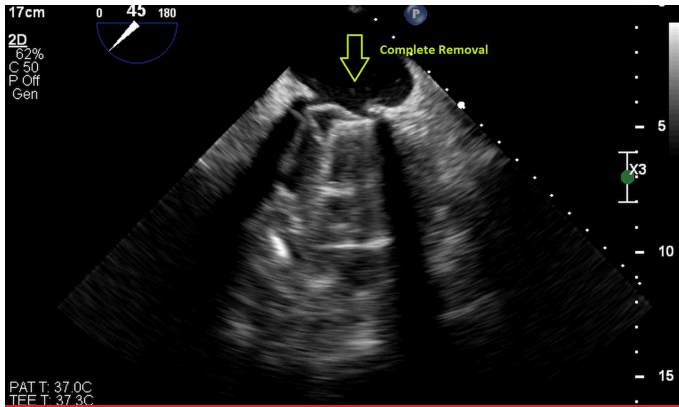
Views of complete removal of thrombus formations in mechanical mitral valve position by transesophageal echocardiography.
